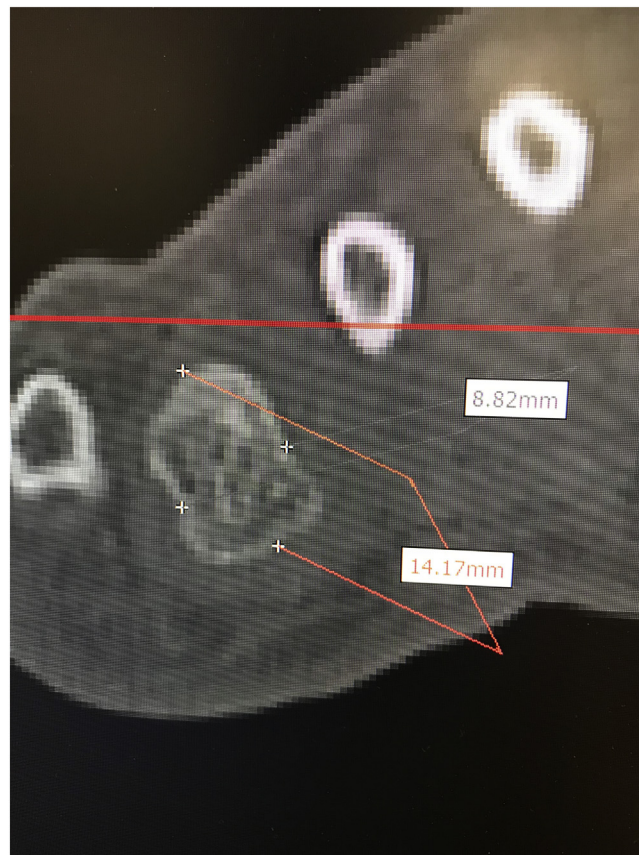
Example of computed tomography (CT) measurement of the height and width of the fourth metatarsal head (coronal plane).
